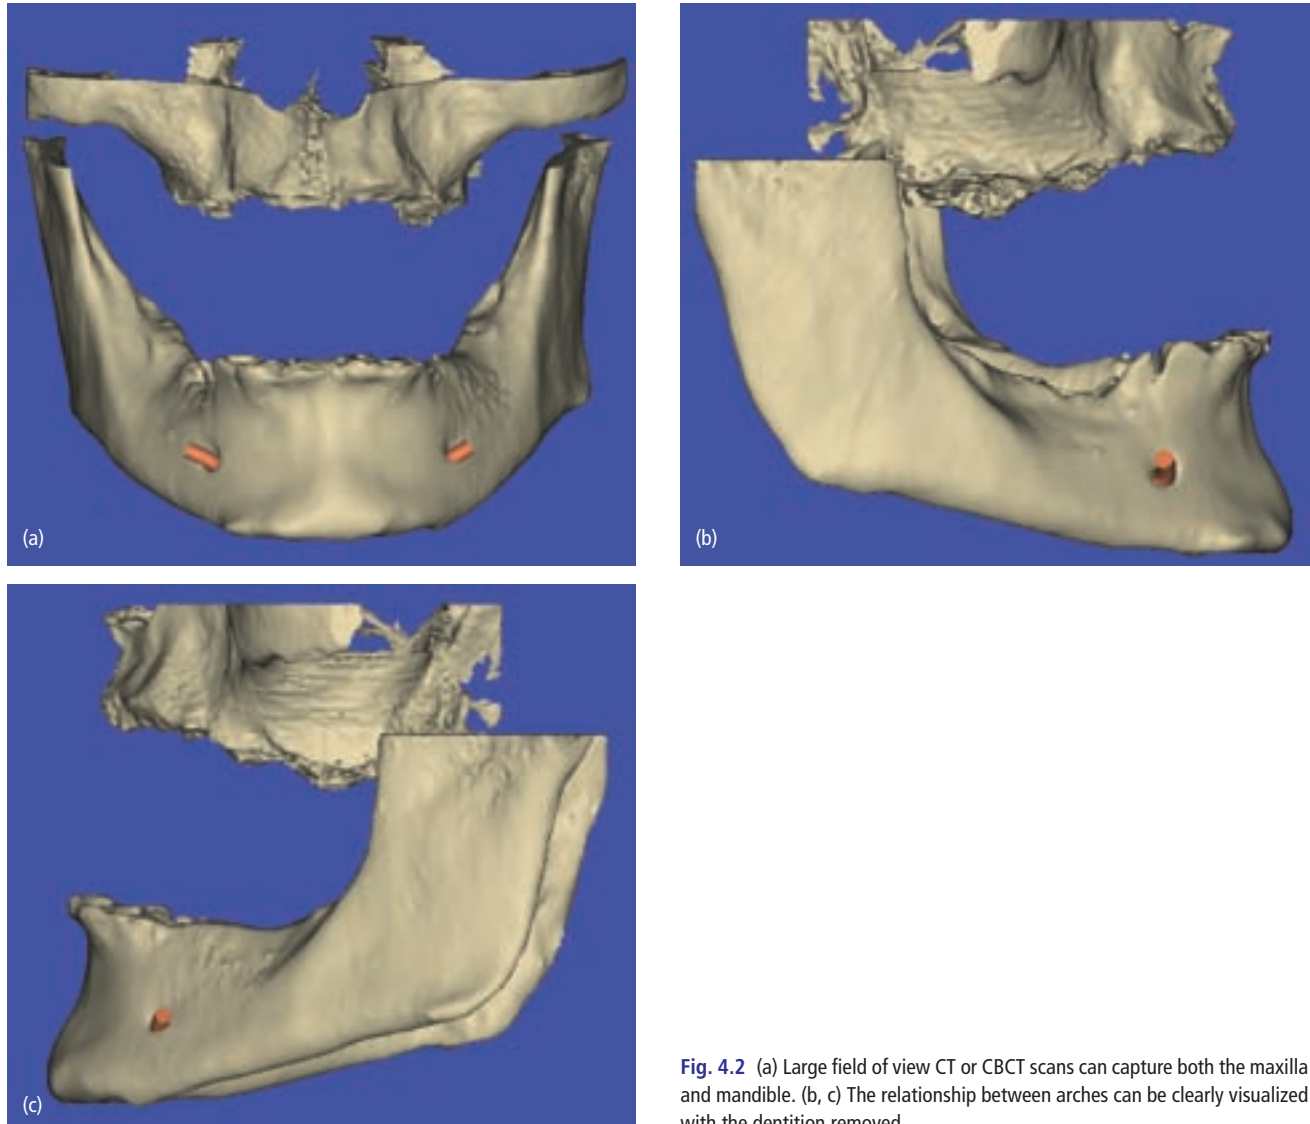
(a) Large field of view CT or CBCT scans can capture both the maxilla and mandible. (b, c) The relationship between arches can be clearly visualized with the dentition removed.
